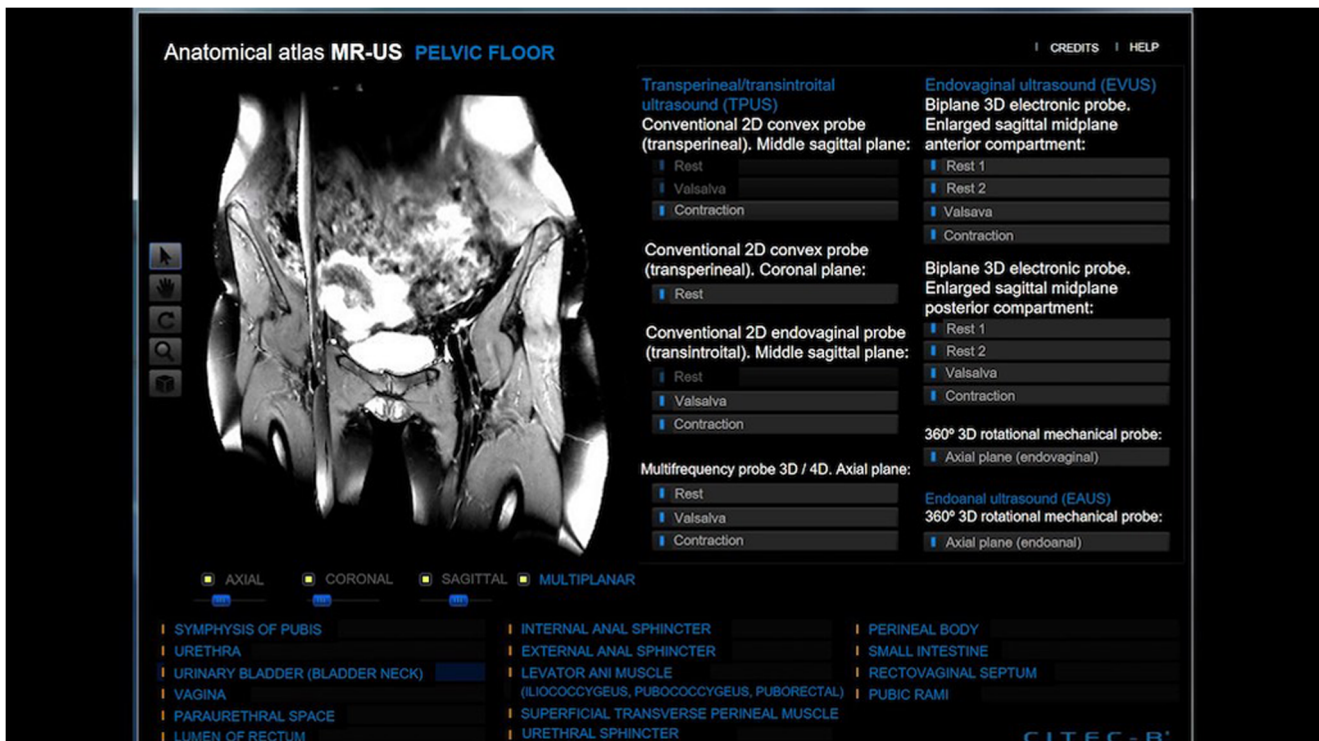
Screen of the anatomico-radiological viewer of the pelvic floor. On the left side MRI with a list of main anatomical structures in the lower area; on the right side the ultrasound vision options are displayed
